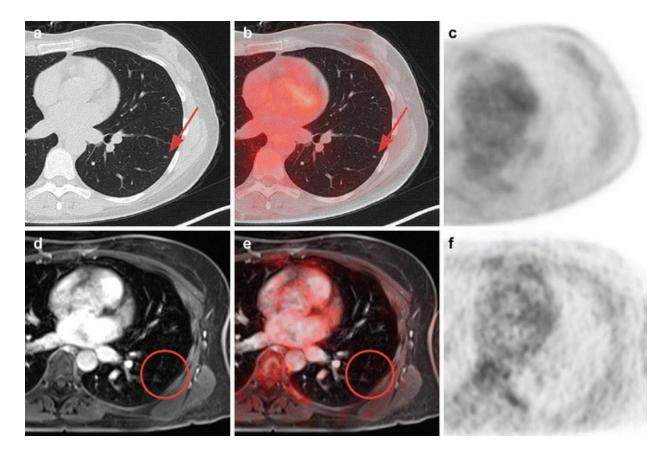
41 year old female patient suffering from malignant melanoma. Morphological, fused and PET images are displayed for PET/CT (\mathbf{a} - \mathbf{c}) and PET/MR (\mathbf{d} - \mathbf{f}). While a small lung nodule without tracer
